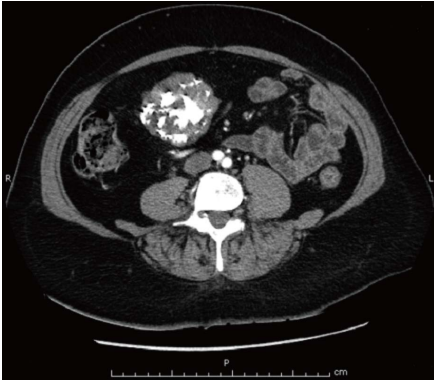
Axial contrast-enhanced computed tomography scan showing a well-defined heterogeneously enhanced gastric mass with coarse and diffuse calcifications.
